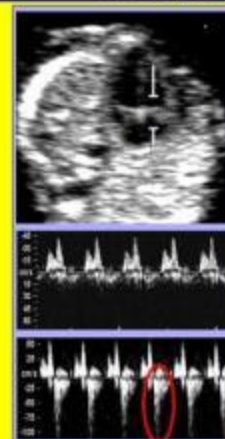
Hypoplastic regurgitation is seen on pulsed Doppler examination of the tricuspid valve in a fetus at 12 weeks' gestation. The velocity of over 1 m/s allows clear distinction from arterial flow, which is usually less than 50 cm/s at this gestational age.
